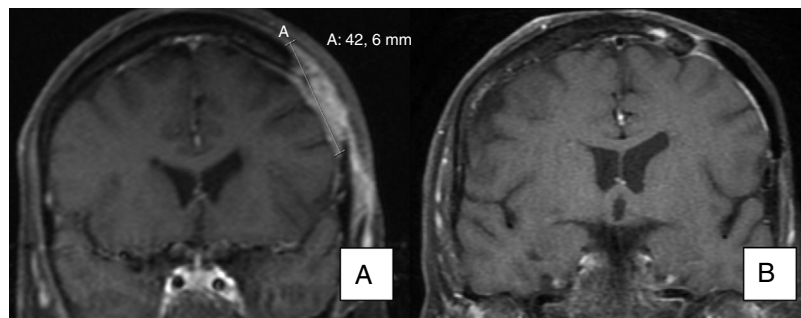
A) Magnetic resonance image showing invasion of bone by the tumor. B) Evidence of radiological resolution after 12 months of treatment (patient 15 in Table 1).
